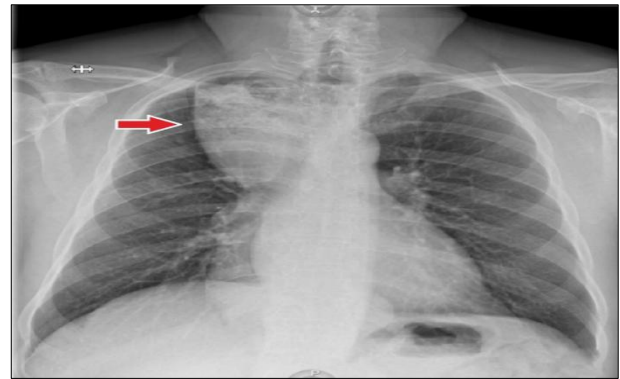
Plain chest radiograph showing esophageal dilation and upward displacement into the right hemithorax (arrow).
